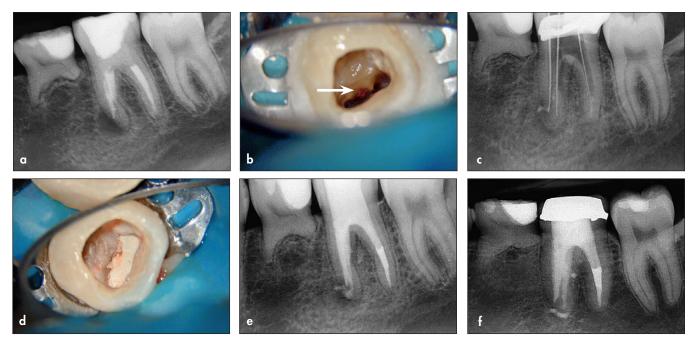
(a) Mandibular left first molar with a mesial root periapical radiolucency in a 13-year-old asymptomatic girl. The molar exhibits both strip and apical perforations from previous root canal treatment. (b) Strip perforation visible under the DOM at the furcal side of the mesial root (arrow). (c) Working length determination after removal of previous obturation material. (d) White MTA canal obturation to the level of the pulpal floor. (e) Final radiograph of obturation and the fiber post and bonded core. (f) Radiograph at 7 years, showing the complete-coverage restoration and complete periradicular healing. The patient is asymptomatic with the molar in full function. (Courtesy of Dr Marga Ree, Amsterdam.)
